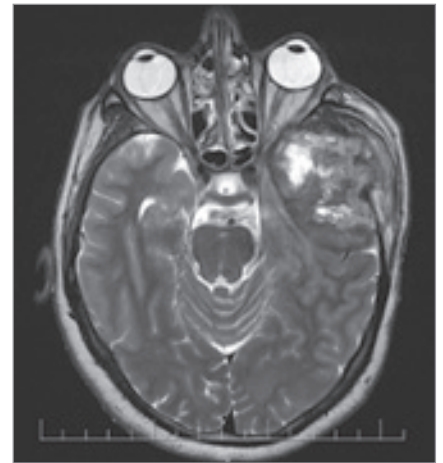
Pre-operative MRI – first case.
